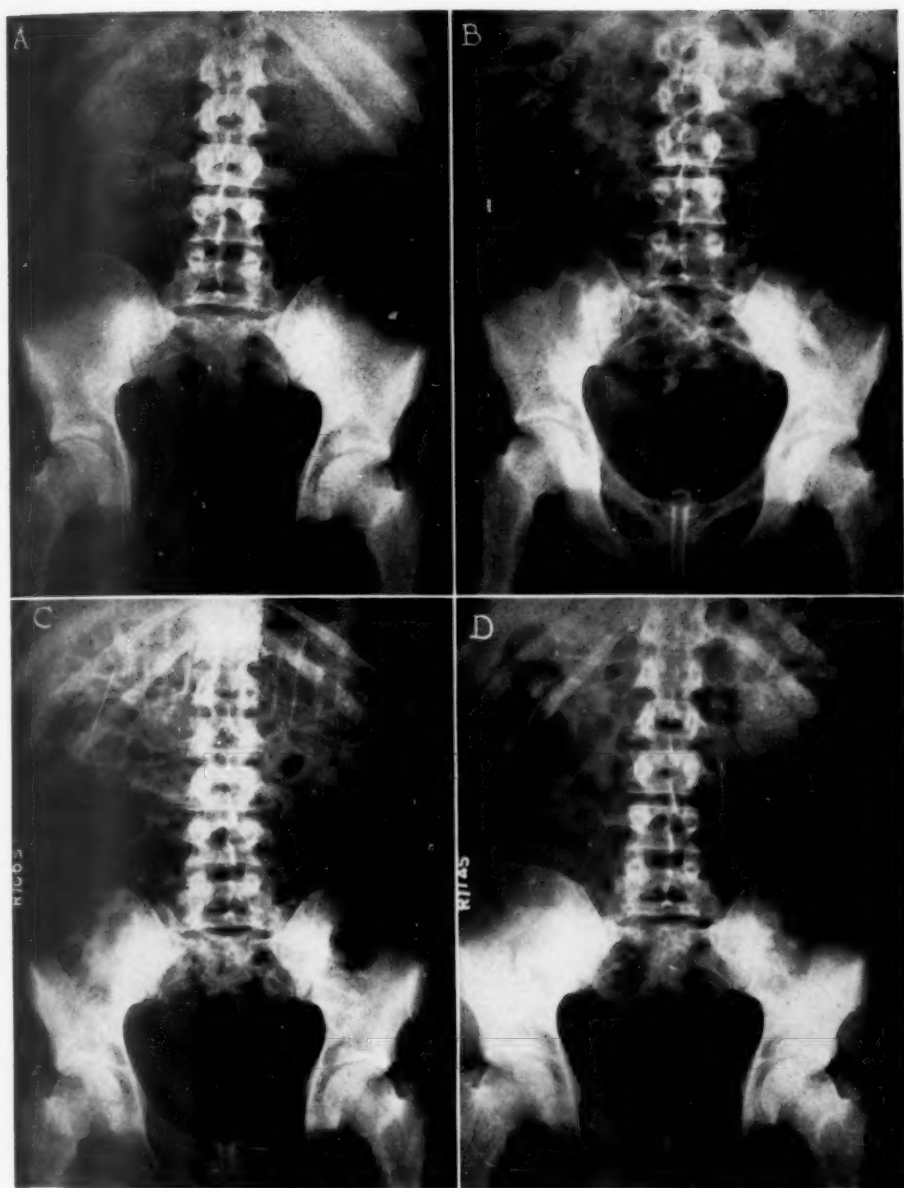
Roentgenograms showing rapid passage of 1000 cc. of oxygen. (L. S.²) (A.) Before the passage of the Levine tube. No gas in the stomach or small intestine and only a small amount in the ascending and descending colon. Oxygen aspiration, which seemed to be no different than air aspiration, was then started. At 18 min. increased gas was seen in the cecum by a following roentgenogram. (B.) At 28 min. Shows the distribution and distention produced by 1000 cc. of gas. Esophageal tube had just been removed. Abdominal girth at umbilicus increased only 2 cm. At 36 min. the first flatus was passed. (C.) At 53 min. Considerable gaseous distention although 500 cc. of flatus had been passed. (D.) At 110 min. Less general distention but still some gas in the distal three-fourths of the colon. Flatus passed 800 cc.
